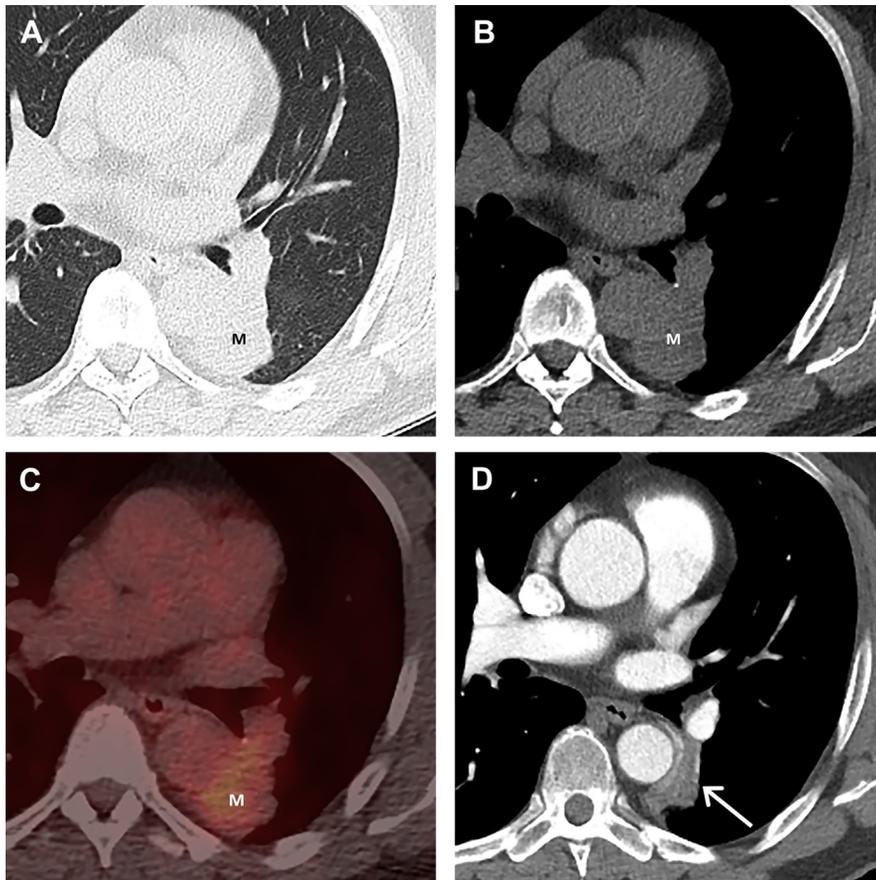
Baseline axial LDCT of a 60-year-old man on (A) lung and (B) soft tissue windows demonstrates a 5-cm mass (M) in the medial left lower lobe. Based on v1 of Lung-RADS, the examination was assigned an overall category of 4B, and diagnostic chest CT, FDG-PET/CT and/or tissue sampling were suggested as possible methods of further management. (C) Fused axial FDG-PET/CT shows only low-grade FDG uptake within the abnormality (M). CT-guided biopsy and bronchoscopic evaluation were then performed and revealed only inflammatory cells without evidence of malignancy. (D) Contrast-enhanced axial CT obtained several weeks after intervention shows marked interval decrease in the opacity (*arrow*) consistent with atelectasis.
